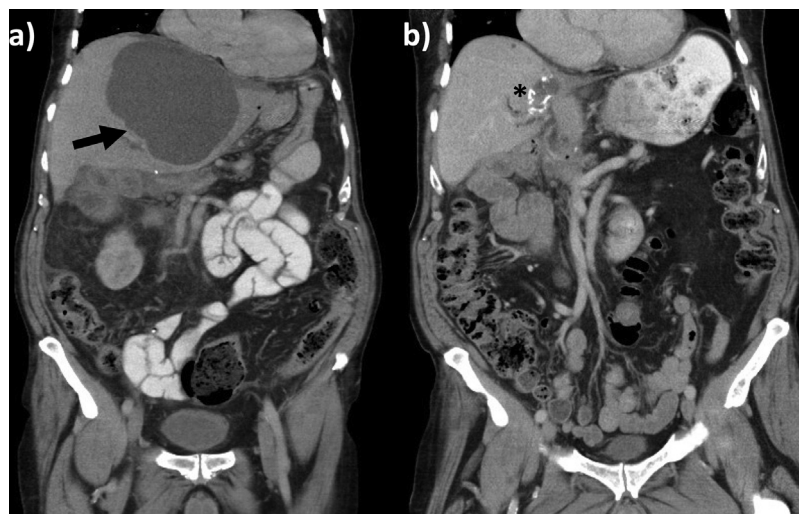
Computed tomography (CT) abdomen that was performed (a) prior to the left lateral segmentectomy and (b) 6 months after the liver surgery. Black arrow denotes a large infected hepatic cyst. Asterisk denotes the resection margin where radio-opaque stapling material can be visualised.
